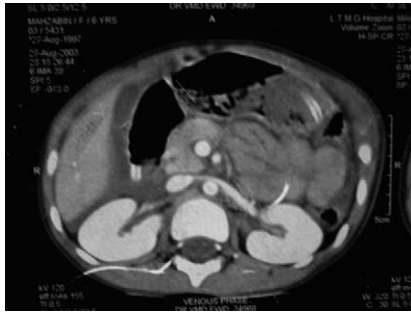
CT scan at that time showed periportal haematoma.
